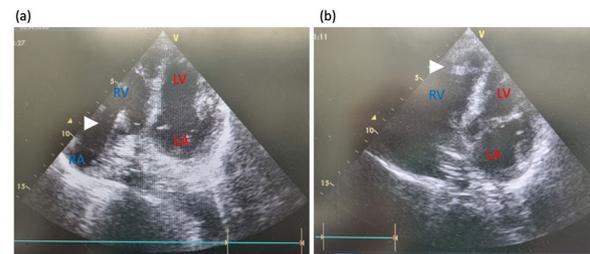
(abstract 000260) . Real-time echocardiography during PICC, Apical 4-chamber view. (a) Catheter heading from RA to RV. (b) Catheter tip on RV. RV; Right ventricle, RA; Right atrium, LV; Left ventricle, LA; Left atrium. Arrowhead; catheter.
